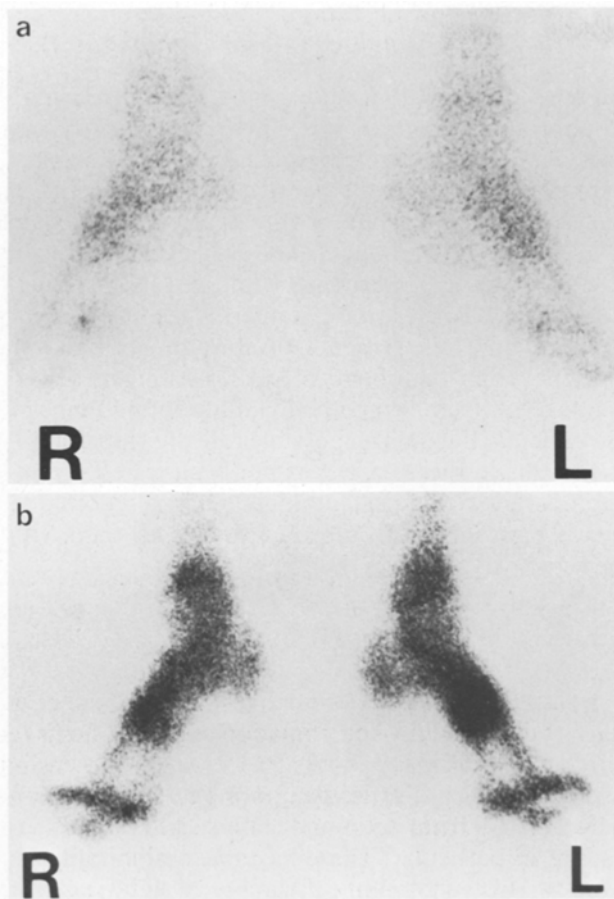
a and b. Visualisation of isotope uptake in the feet of a normal person (a) and of a diabetic woman, aged 35 years, with severe neuropathy (b). X-rays of the feet were normal
